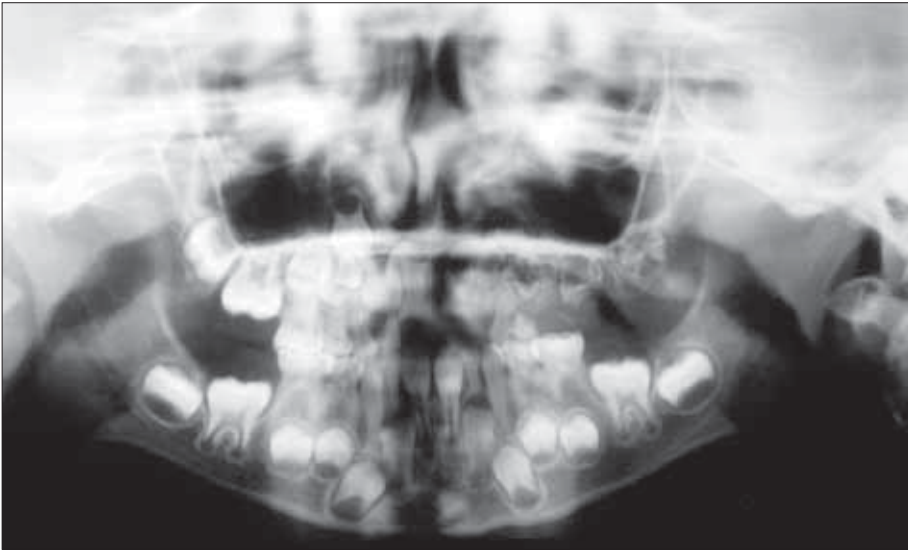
Panoramic radiograph of the patient at age 5 showing involvement of the upper right quadrant.
